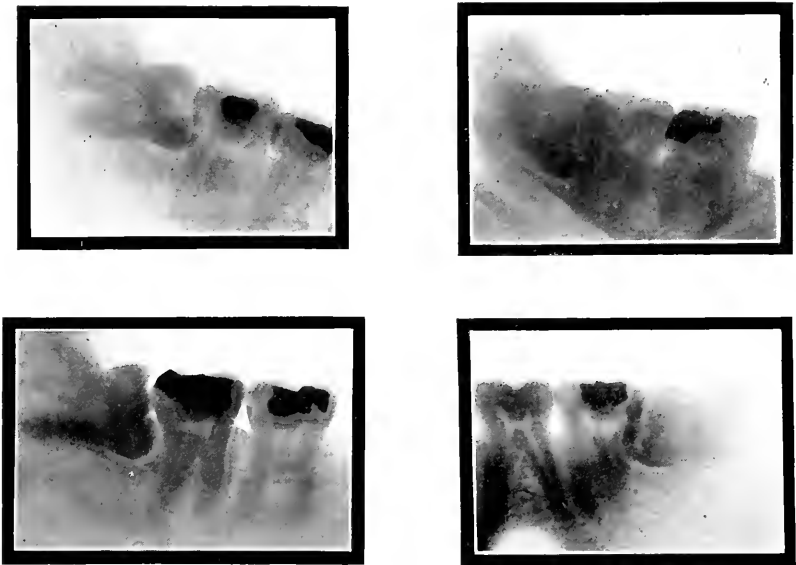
Radiographs of impacted inferior third molars. The occlusal surface of the third molar impinges on the second molar, with the roots of the impacted tooth markedly spread or hooked.
